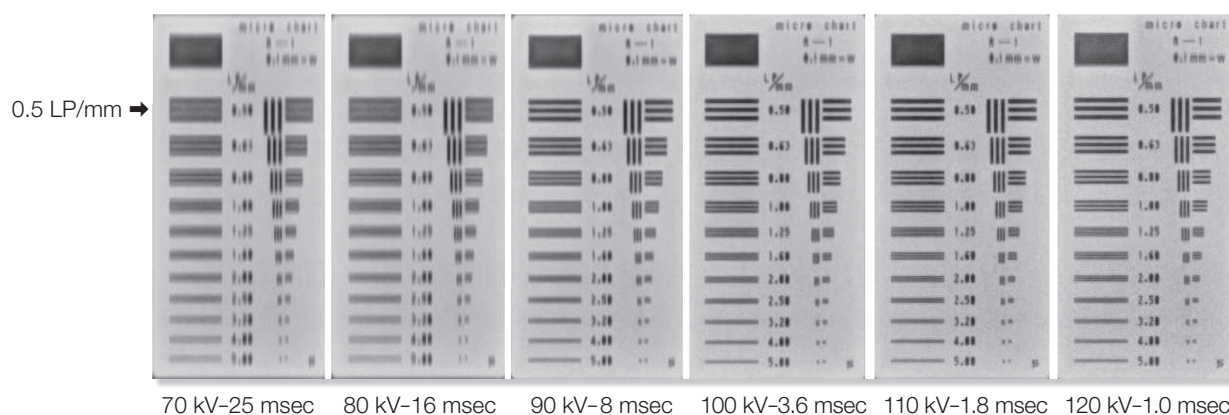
X-ray chart image (10 cm) according to the difference of imaging conditions
